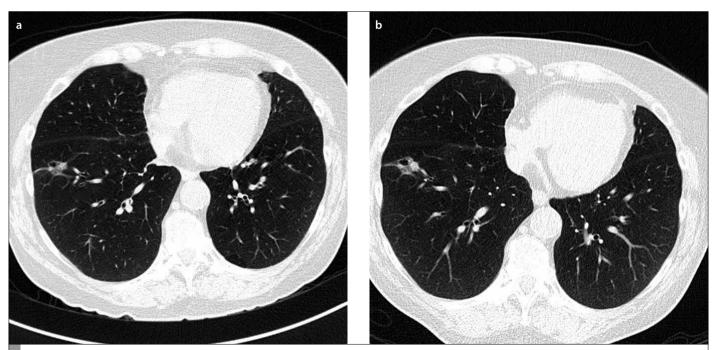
a, b. This low-dose screening CT scan was read out by the radiologist as showing a 1.6 -cm focal course linear density and irregular consolidation in the anterior right lower lobe (a). The patient was followed with CT scans at 4 months and 10 months, and the lesion was stable. A following CT scan 14 months after the initial CT scan demonstrated enlargement and measured 1.9 cm. At resection, it proved to be a low-grade adenocarcinoma, Stage IA (b).
